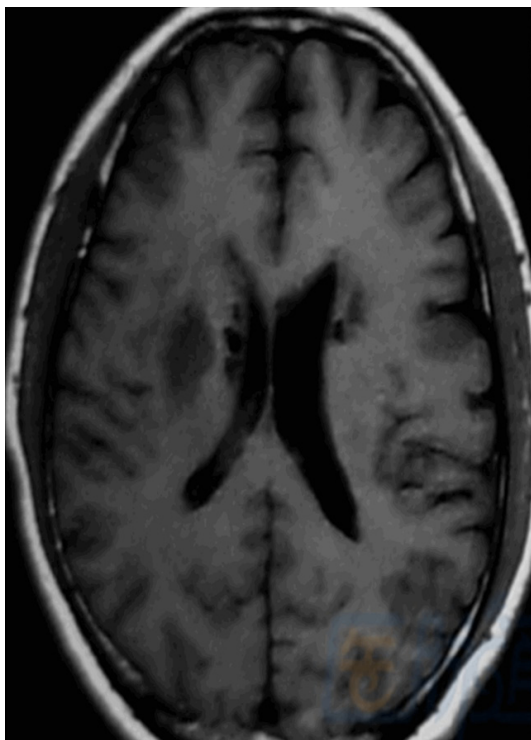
T1WI performance in MRI.
